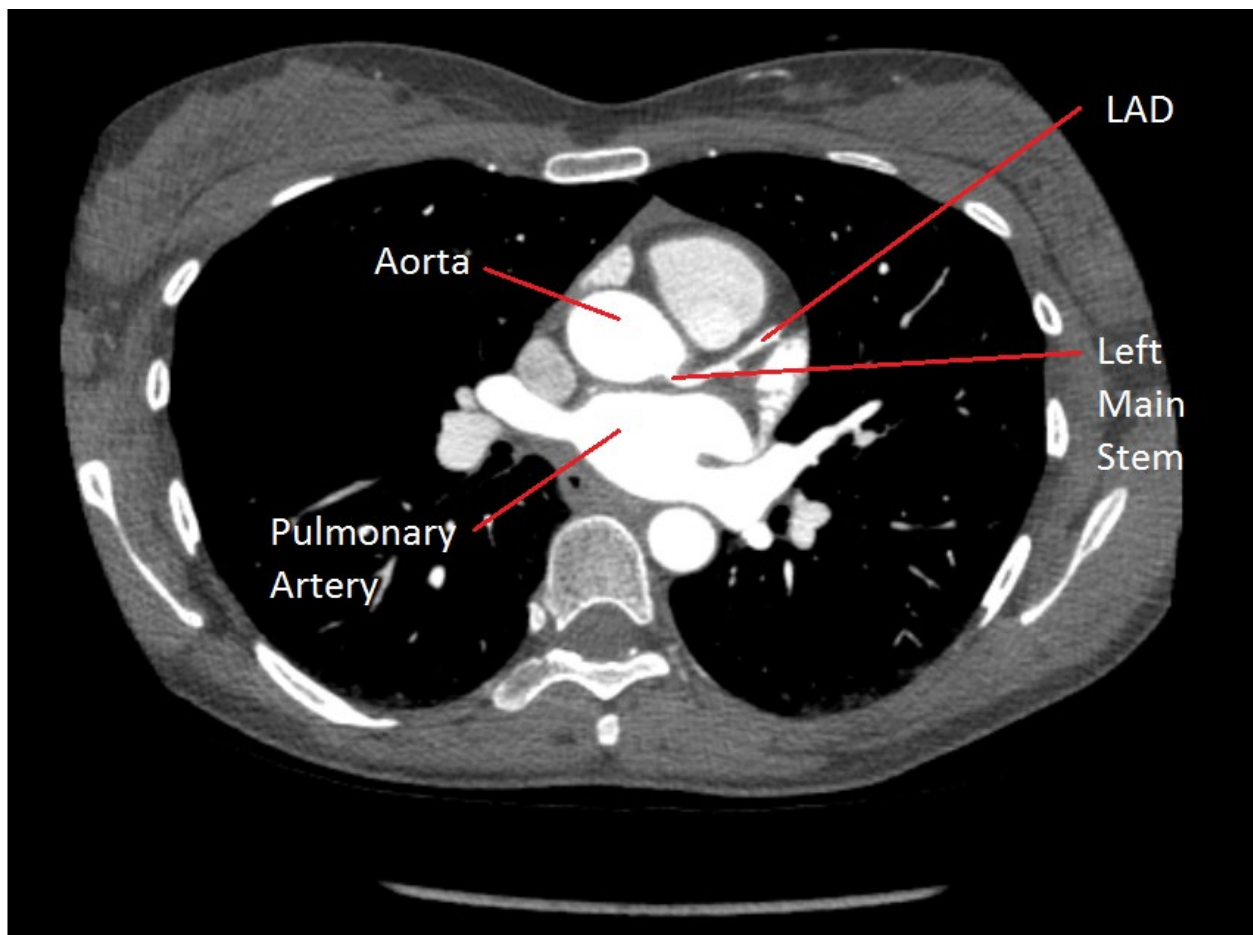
Cardiac CT Showing Coronary Anatomy. LAD = left anterior descending artery. Permission for image use obtained.
